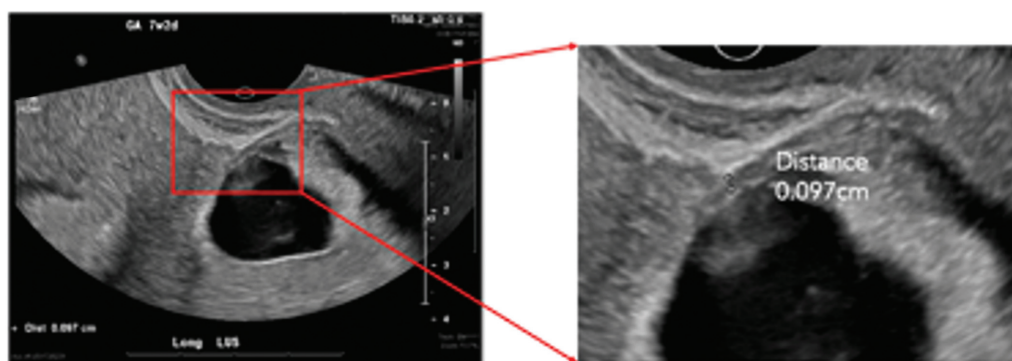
Transvaginal ultrasound (TVUS) on hospital day 2, demonstrating thin myometrium (0.097 cm) anterior to the gestational sac of fetus B.
